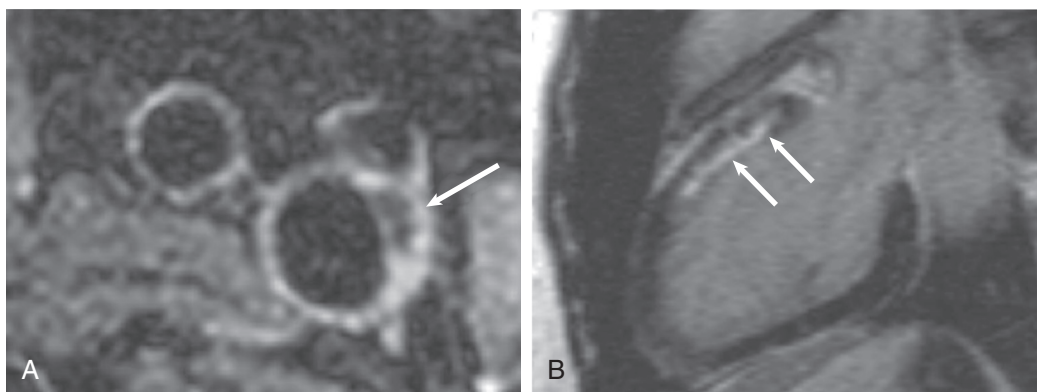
Atherosclerosis in SLE. A, Transaxial T2-weighted CMR of the carotid bifurcation showing atherosclerotic plaque (arrow). The lipid-filled core and fibrous cap can be seen along with evidence of calcification. B, CMR showing a two-chamber view in the late phase after gadolinium injection. Subendocardial late gadolinium enhancement is present in the anteroapical left ventricle (arrows) and extends from the base of the heart to the midventricular region, consistent with a previous subendocardial myocardial infarction.
